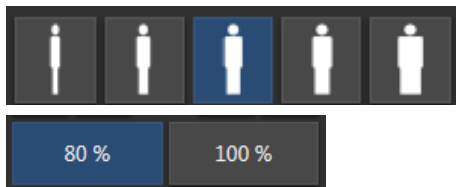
Settings for patient size and X-ray tube load
